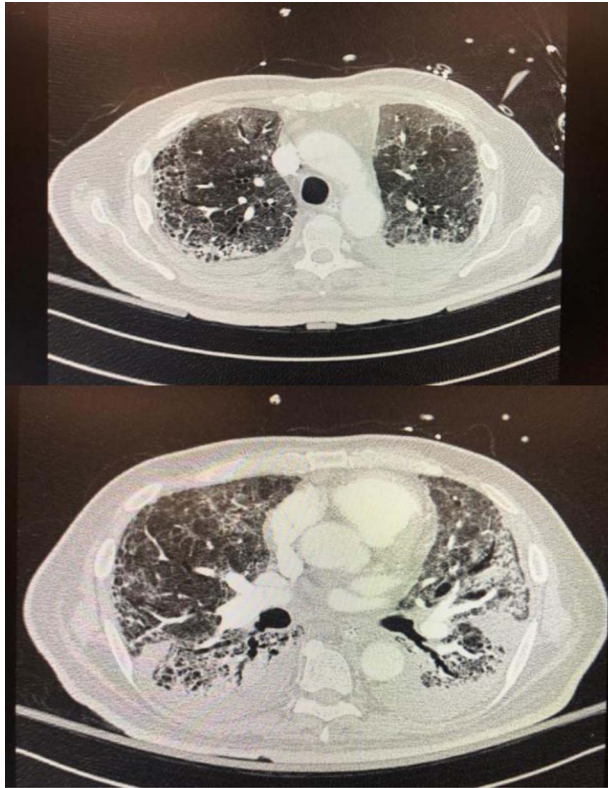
Nonenhanced CT chest on day 35 showing subpleural and interlobular thickening with honeycombing, ground-glass opacities, and traction bronchiectasis bilaterally.
